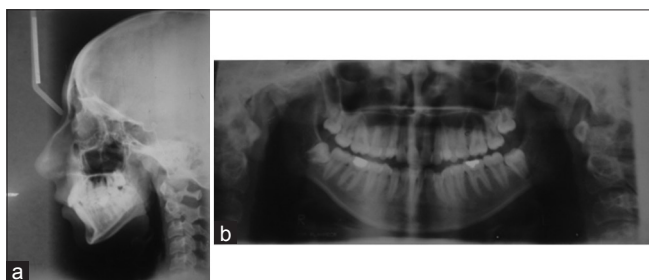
Pre-treatment radiographs. (a) Lateral cephalograph (b) Orthopantomogram.
